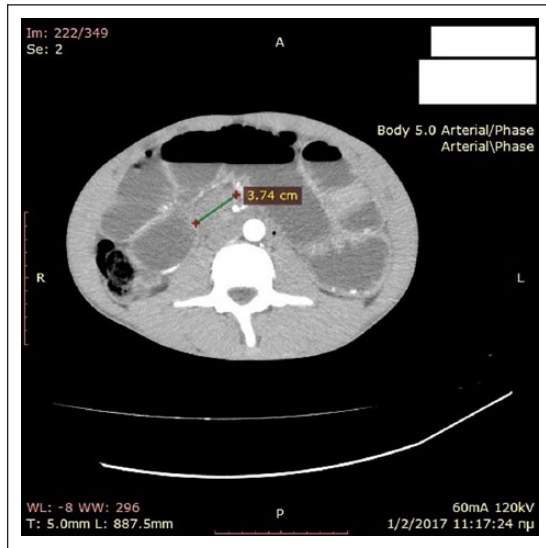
Contrast-enhanced abdominal CT demonstrating small bowel obstruction signs with distended small bowel loops and diffuse multiple air-fluid levels and a mass possibly of lymphatic constitution with a proximately 3 cm diameter on the mesentery.
